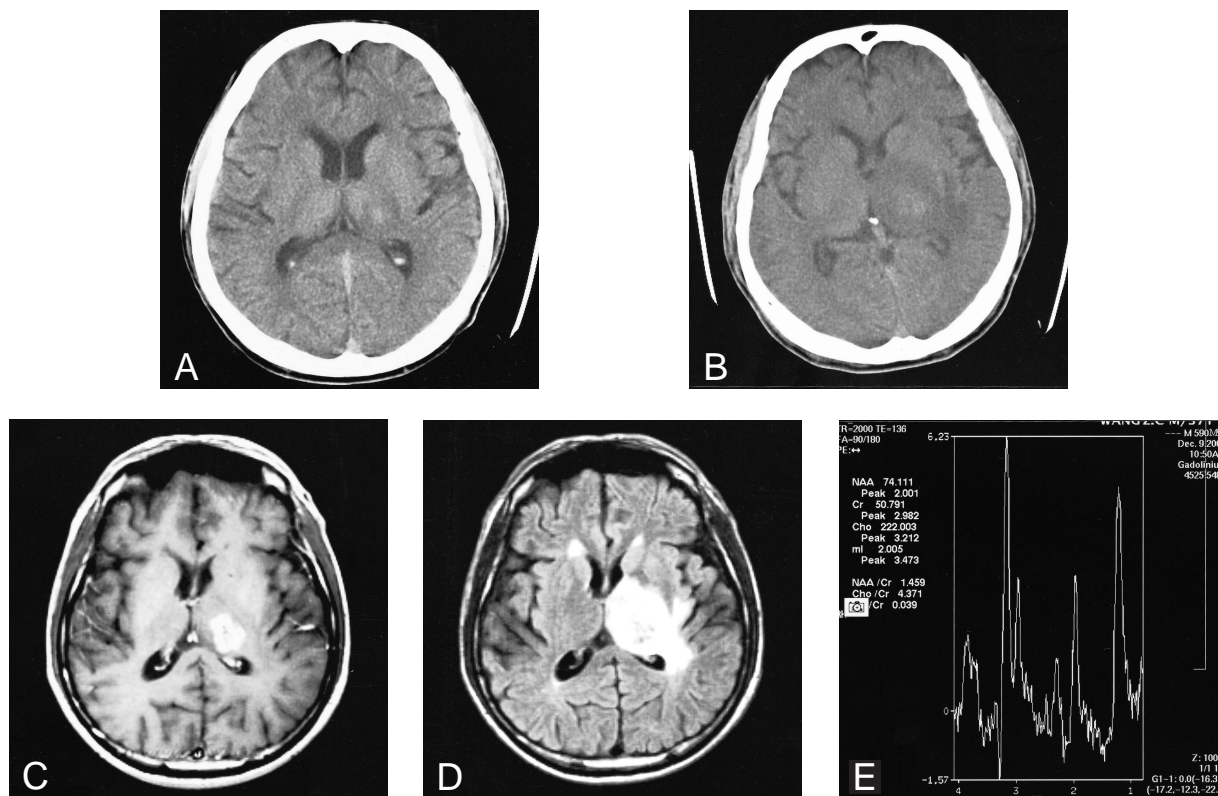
A: Three months before surgery, non-contrast CT scan disclosed a slightly high-dense lesion at the left thalamus with perifocal edema and relatively early brain atrophy. B: Three days prior to surgery, non-contrast CT scan revealed that the central high dense lesion had enlarged and the perifocal edema had become more prominent. C: Axial T1WI with contrast disclosed a well-enhanced mass in the left thalamus with irregular margins and central necrosis. D: Axial FLAIR revealed a central hypointense lesion with severe perifocal white matter edema. E: Proton MRS shows increased choline/creatine ratio, increased lipid/creatine ratio, and decreased N-Acetylaspartate/creatine ratio. (The peak of N-acetylaspartate, $\times = 2.0$; creatine, $\times = 3.0$; choline, $\times = 3.2$; and lipid, $\times = 1.2$ ppm).
